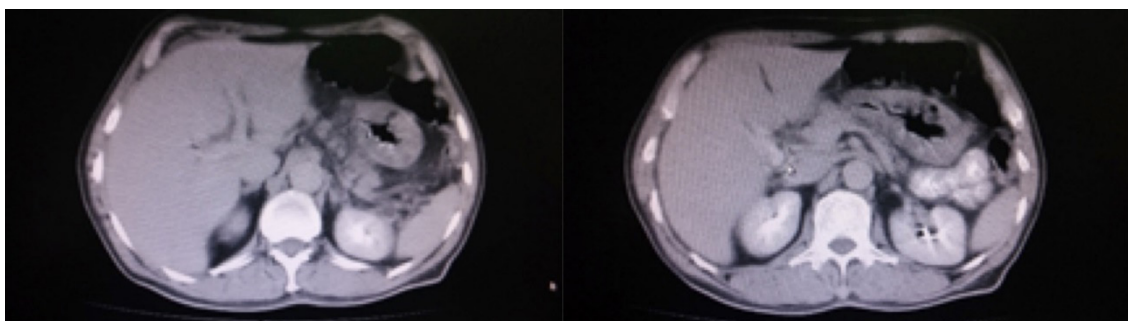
Control CT image at the 3rd day of hospitalization
